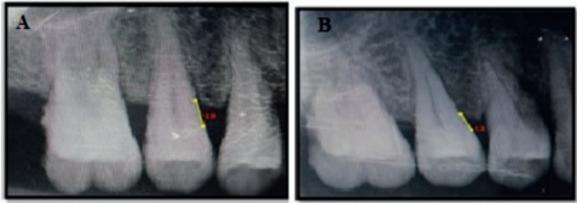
(A)-Pre treatment radigraph (B)-Post treatment radiograph
